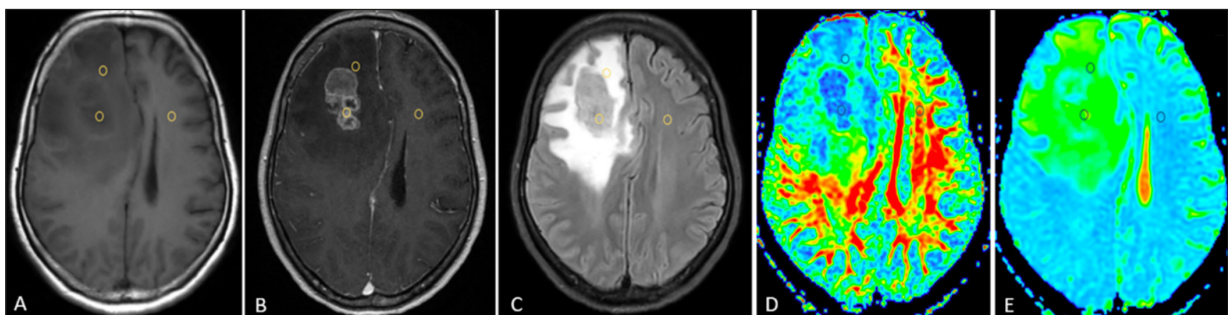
A 50-year-old woman with right frontal solitary brain metastases originating from lung cancer. Pre-contrast T1-weighted T1W (A), post-contrast T1W (B), and fluid-attenuated inversion recovery (C) images show a tumor with strong and heterogeneous enhancement and moderate peritumoral edema. Three regions of interest were placed in a solid component of the tumor, the peritumoral edema region, and the opposite normal white matter and measured using the FA (D) and MD (E) maps.
